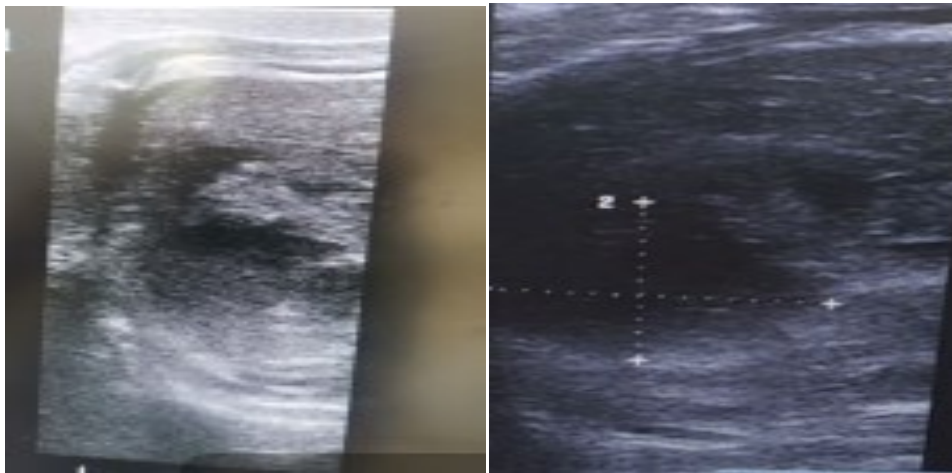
Abdominal ultrasound images showing ill-defined mixed hypo echoic and anechoic liver lesion.
